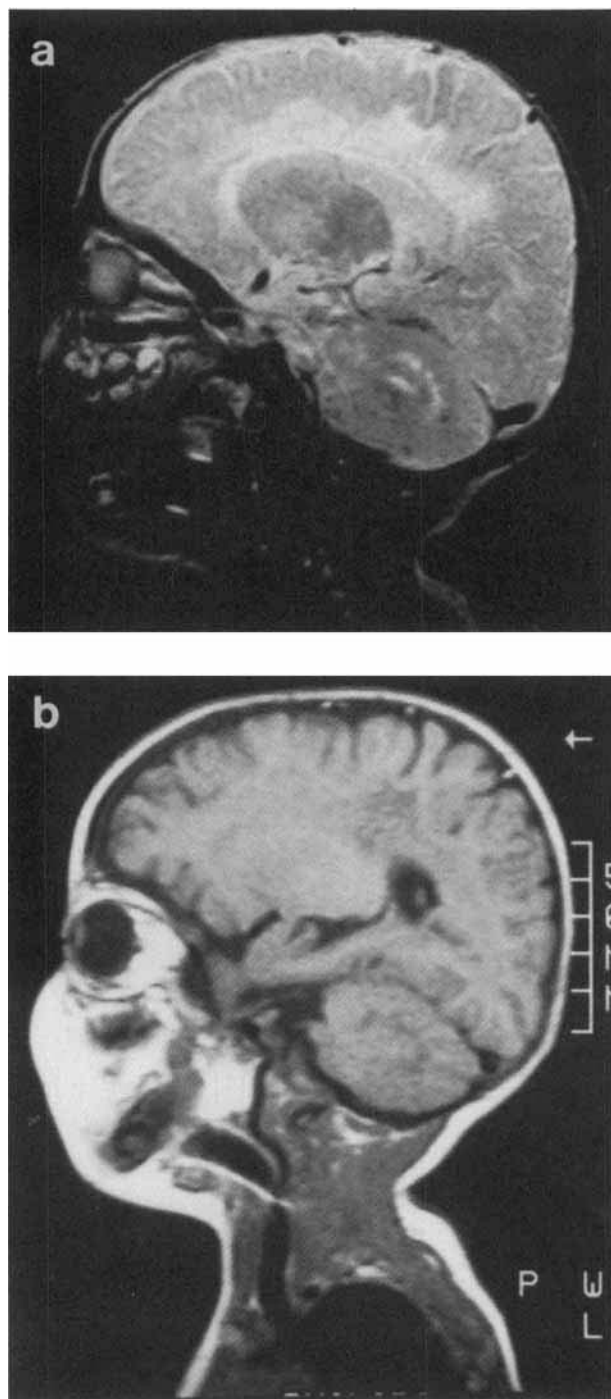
MRI in KD, infantile form. Case 2. Six-month-old child presenting with developmental delay and severe generalized hypertonicity. a: Parasagittal MRI T2-W: Spinecho (SE) 2,000 msec; Repetition time (TR) 2,000 msec; Echo time (TE) 80 msec. Increased signal in centrum semiovale and cerebellar white matter. Decreased signal in thalamus and dentate nucleus. b: Parasagittal MRI T1-W (SE, TR, 520 msec; TE, 20 msec). Slightly decreased signal in centrum semiovale and cerebellar white matter.
